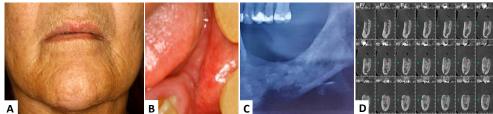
Clinical and imaging features of initial lesion. A Extraoral examination with mild facial edema on left side. B Intraoral examination with intact alveolar mucosa and slight purulent drainage associated with tooth 33. C Orthopantomography (OP) showed an extensive destruction of left mandible bone and mixed areas of sequestration. D Sagittal slices by CT showed pathological fracture of mandibular baseline.
